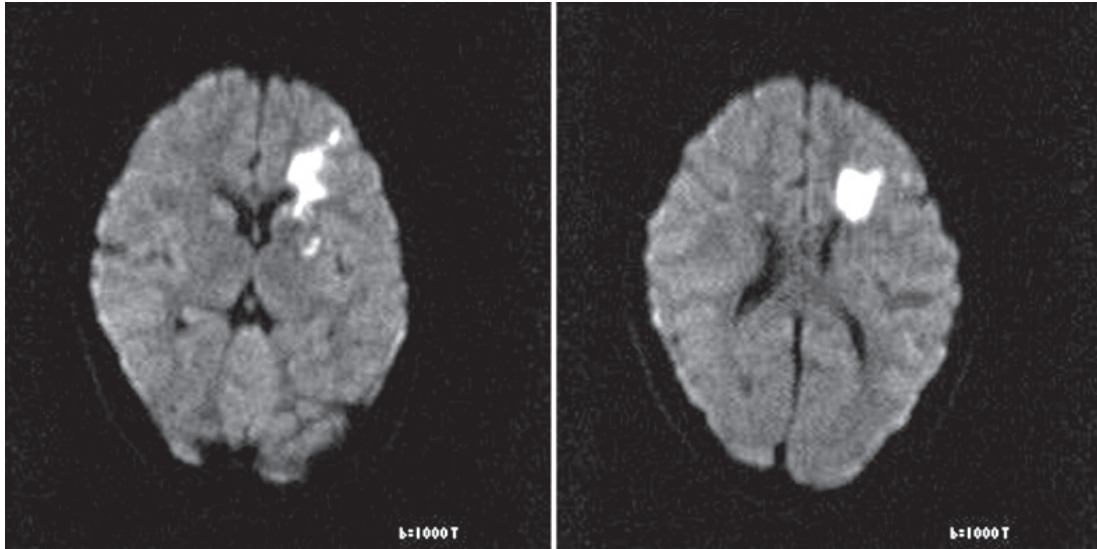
Diffusion-weighted magnetic resonance imaging shows an area of abnormally increased signal intensity in the left frontal lobe, consistent with anterior border zone infarction.
